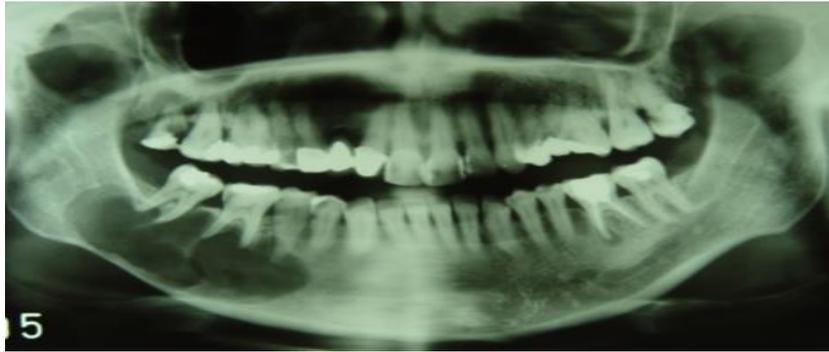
a.- Panoramic X-ray showing a radiolucent shadow compatible with Amaloblastoma.
